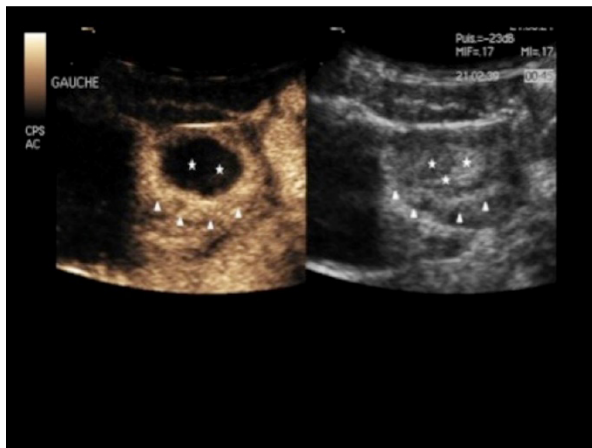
CEUS and B-Mode ultrasound: absence of ovarian torsion and haemorrhagic cyst: no enhancement of the heterogeneous haemorrhagic cyst (asterisk) and normal enhancement of the surrounding healthy ovarian tissue (triangles).
